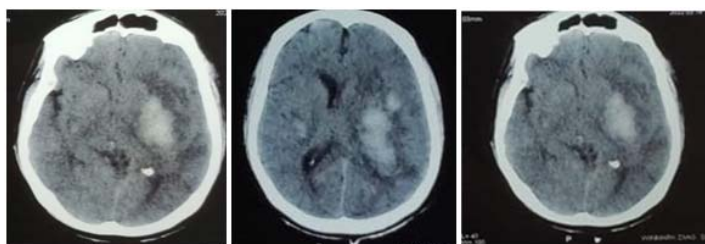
CT Imaging from a patient of Basal Ganglia hemorrhage in the present study
